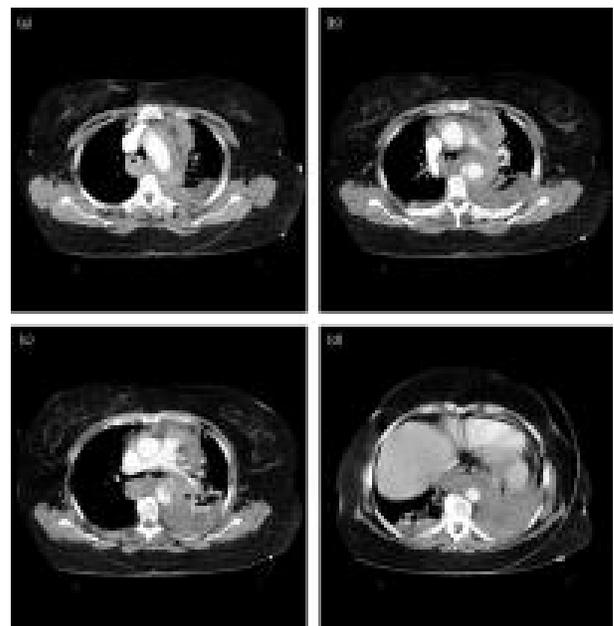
Initial contrast computed tomography imaging of thorax. (a) Above the level of transection; (b) and (c) at the level of aortic injury; (d) below the level of aortic injury
